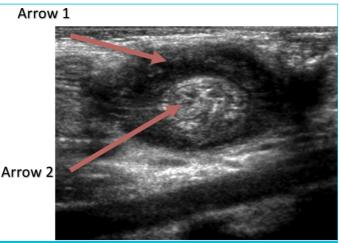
Abdominal intussusception on ultrasound, with arrow 1 indicating a hypoechoic edematous outer loop and arrow Two hyperechoic compressed bowel loops are telescoping within.
